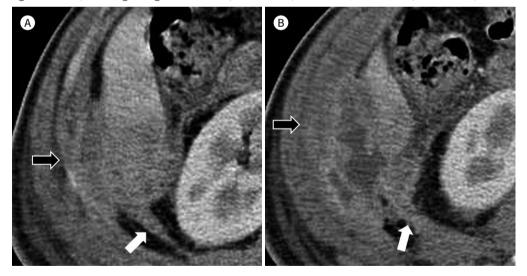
Hepatic inflammatory pseudotumor in a 63-year-old man who presented with right flank pain. A, B. Post-contrast CT demonstrates a delayed-enhancing mass with spiculated margins at the tip of the right hemiliver, involving the right renal fascia (white arrows) and the abdominal wall (black arrows).
